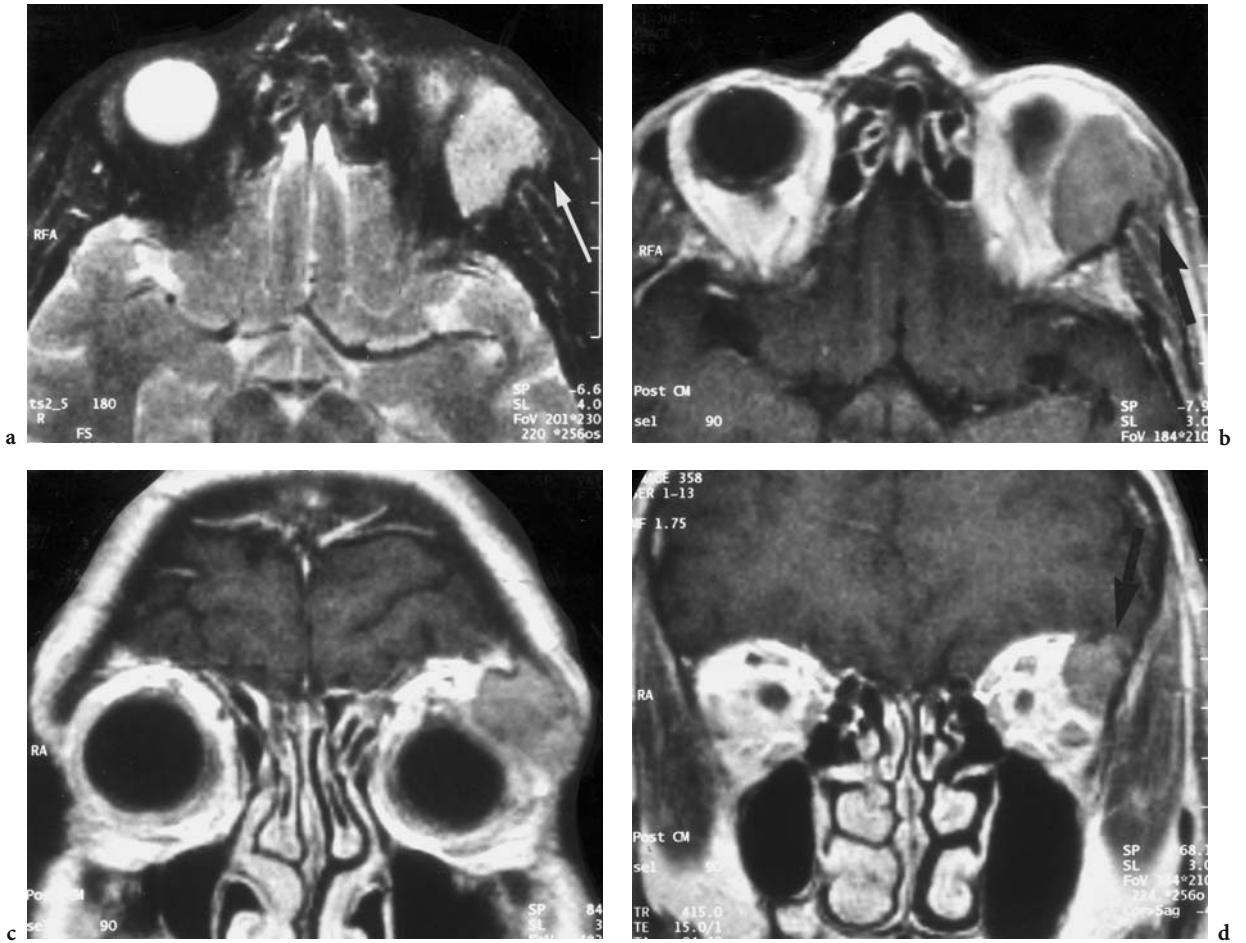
A 59-year-old woman presenting with subacute, left, extra-axial proptosis and enlarged lacrimal gland. Diagnosis: malignant NHL (B-cell type). MR: a Axial T2-weighted image, a comparison with the right side clearly demonstrates both enlargement of the left lacrimal gland and destruction of the zygomatic bone (*white arrow*). b Corresponding T1-weighted, contrast-enhanced view showing the loss of cortical integrity of the upper lateral orbital wall with tumor extension to the subcutaneous fat (*arrow*). c Coronal T1-weighted, contrast-enhanced view with demonstration of the irregular tumor mass. Note the compression exerted by the tumor leading to inferior dislocation and flattening of the globe. d Corresponding image of the posterior part of the orbit, visualizing tumor destruction of the orbital roof and intracranial, but extradural extension (*arrow*)
